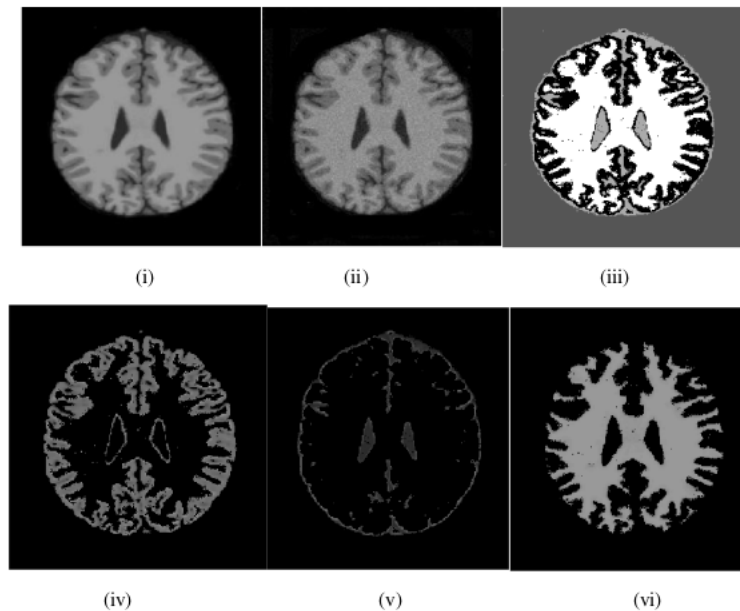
(i) MRI T1-100, (ii) MRI with 5% noise, (iii) MRI segmented using ACO-FCM, (iv) MRI with Gray, (v) CSF, (vi) MRI with White
